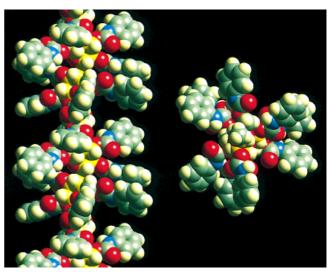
Optimized structure of CTPC based on the structure determined by X-ray analysis.^[45] The glucose carbon atoms of CTPC are shown in yellow for clarity. View along the helix axis (left) and perpendicular to the helix axis (right).
